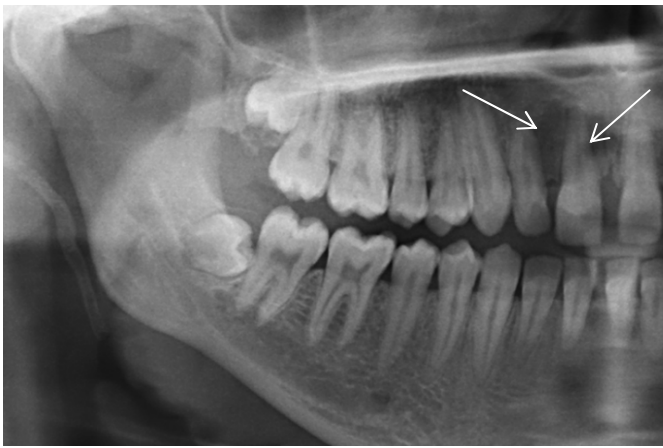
Cropped Digital Panoramic radiograph of the right side showing well defined unilocular radiolucency measuring approximately 9x7mm in size irt 11 and 12
